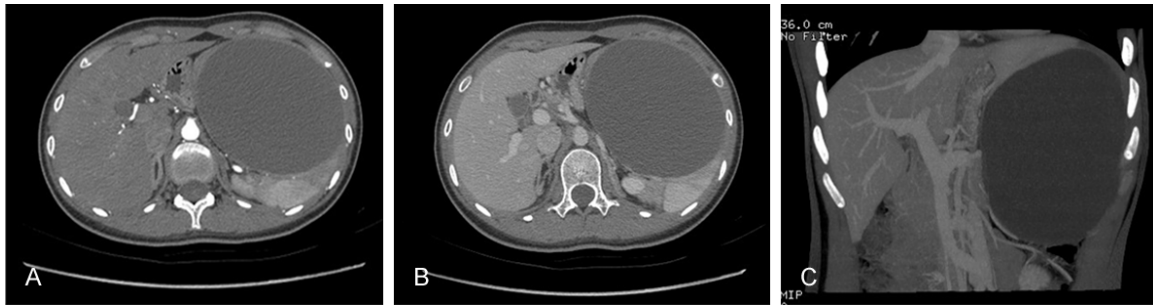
A-C. Preoperative CT showing a huge splenic cyst located in the lower pole segment of the spleen.
